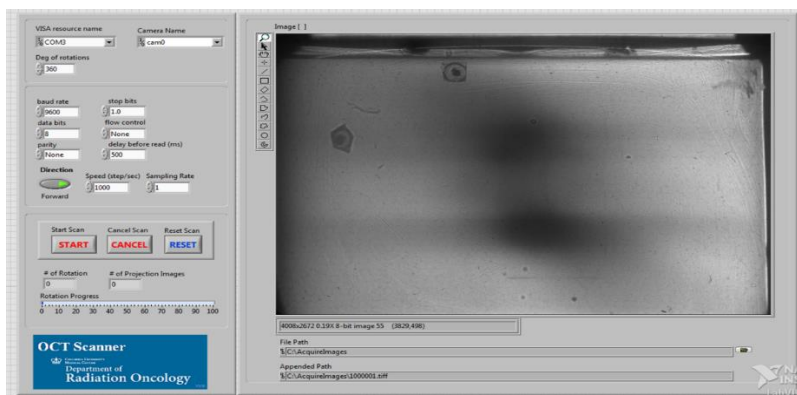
User interface of the developed optical CT scanning software. The left side of the interface presents the scanning parameters and control buttons, while the right side displays real-time projection images of the scanned dosimeter.
